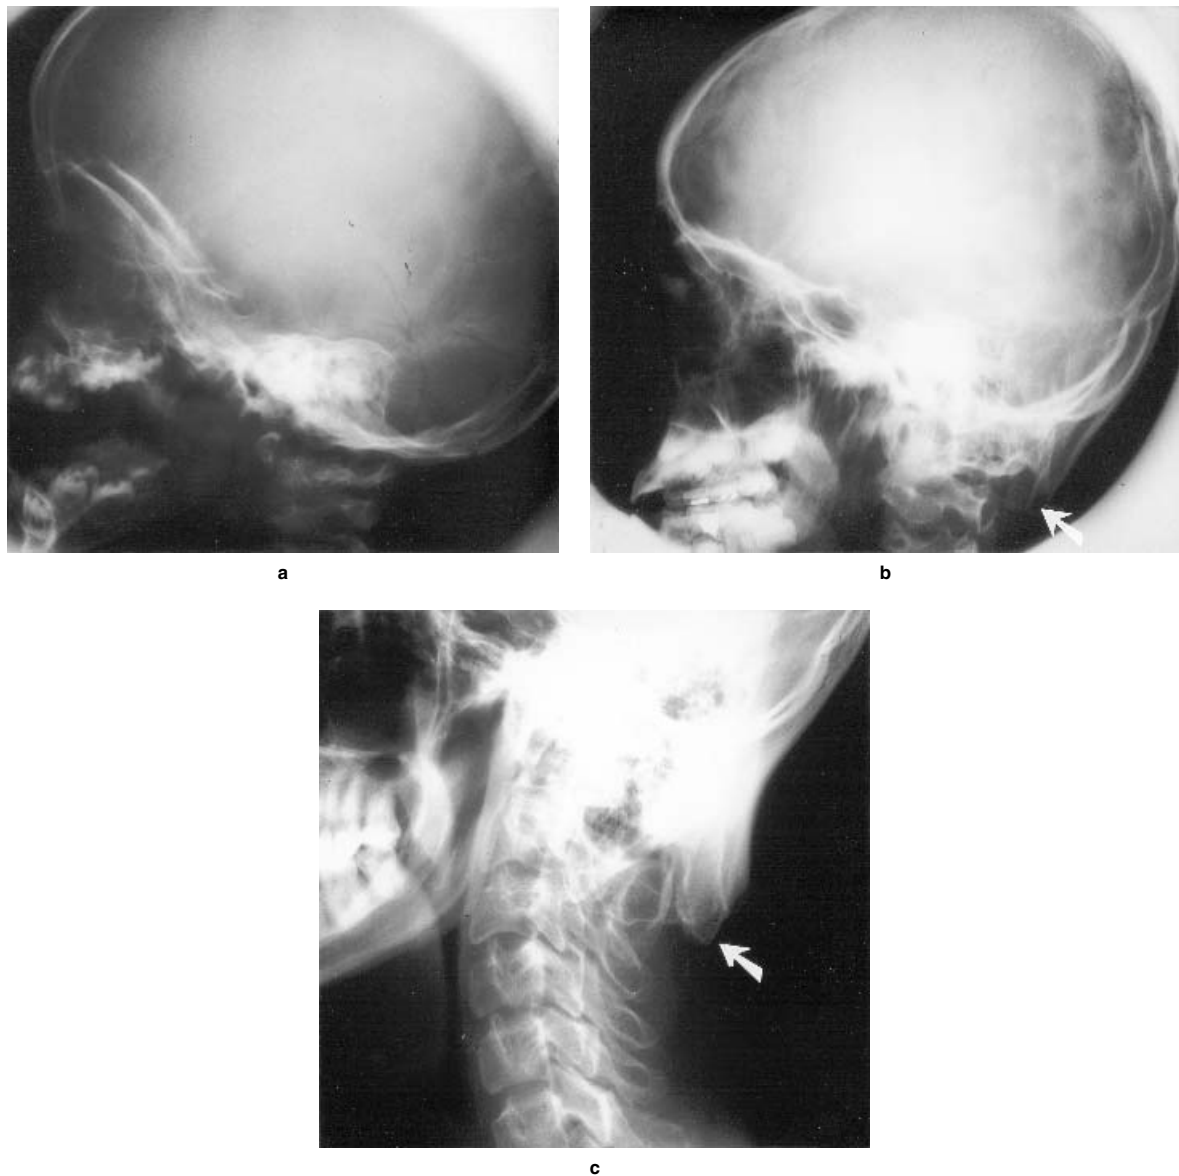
Lateral skull radiographs of the same patient as in Figure 8, demonstrating occipital horns. The skull at age one year and four months shows no signs of occipital exostoses (a). The skull at nine years of age demonstrates typical occipital exostoses (arrow) (b). At age 23 years, the occipital exostoses become more prominent (arrow) (c). (Courtesy of I. Kaitila, Helsinki University Hospital, SF-00290 Helsinki, Finland.)
